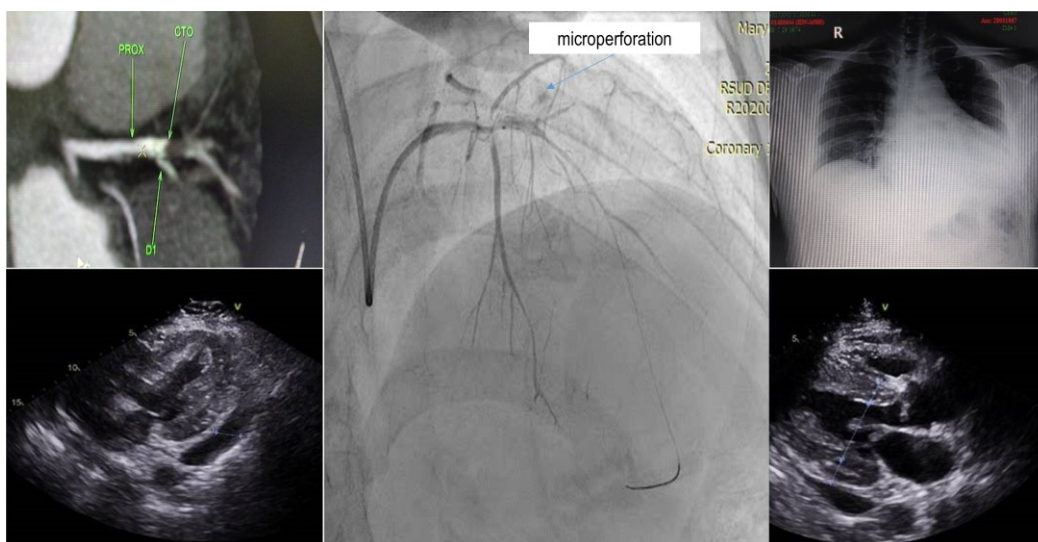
CCTA revealed CAD-RADS 5 and total occlusion in mid LAD. Echocardiogram showed moderate pericardial effusion and x-ray revealed left pleural effusion. In CAG-PCI procedure, revealed microperforation during index procedure and treated with stenting 1 DES Proximal-Mid LAD
